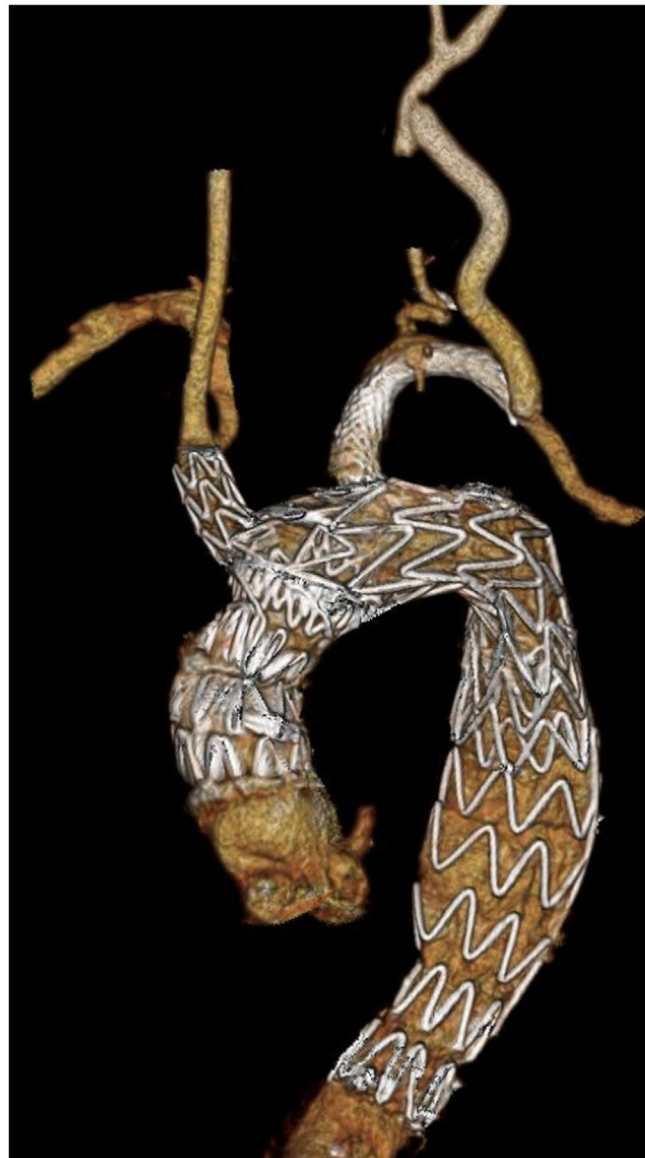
Three-dimensional reconstruction of a computed tomography (CT)-angiogram of a patient with chronic residual thoracoabdominal dissection with previous ascending aorta replacement successfully treated with Nexus Duo endograft. One side branch supplies the brachiocephalic trunk (BCT) and the inner branch guarantees blood flow to the left subclavian artery (LSA). It required LSA-left common carotid artery (LCC) bypass.
